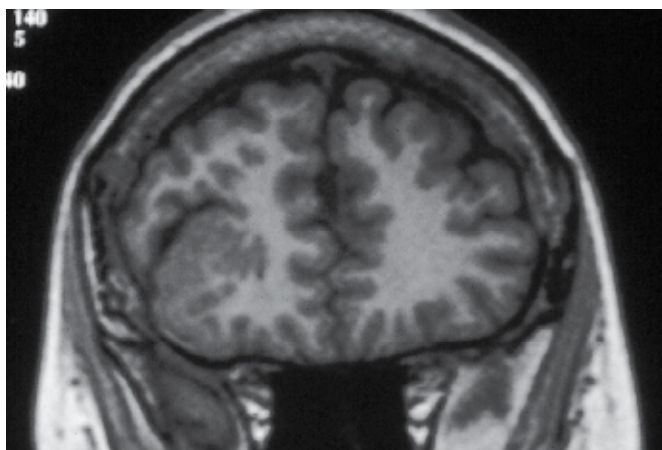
Magnetic resonance image of a frontal polymicrogyria.
